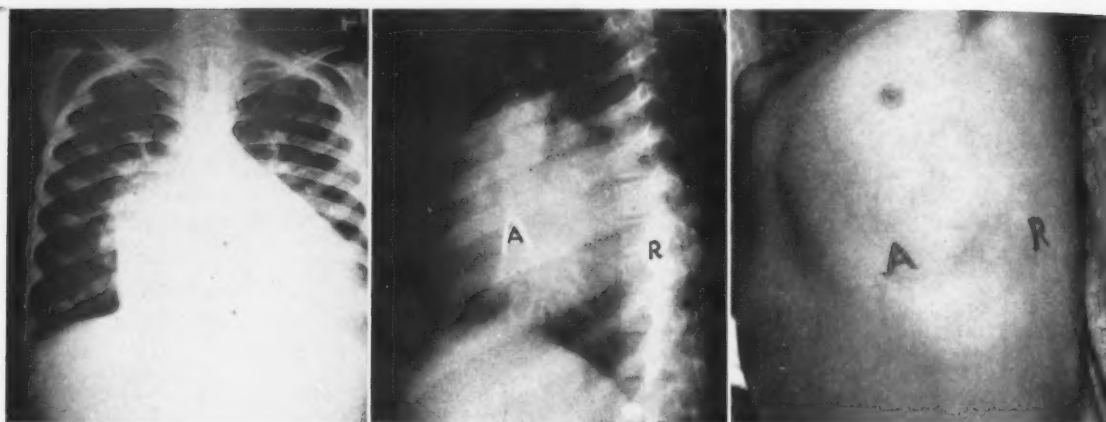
Left*, chest roentgenogram in the frontal view. The space of clear lung field between the chest wall and the heart is resonant to percussion, a fact which permits an accurate location of the apex. *Center*, left oblique view at 60 degrees. The letter *A* corresponds to the anterolateral aspect of the right ventricle and to the site found by palpation ("apparent" apex). The letter *R* is at the site of the "real" apex (left ventricle). These facts are confirmed fluoroscopically. *Right*, the chest of the same patient. The letter *A* corresponds to the "apparent" apex; the letter *R* to the "real" apex found clinically. (Courtesy of Drs. Dorbecker, Corominas and Ambia.)
